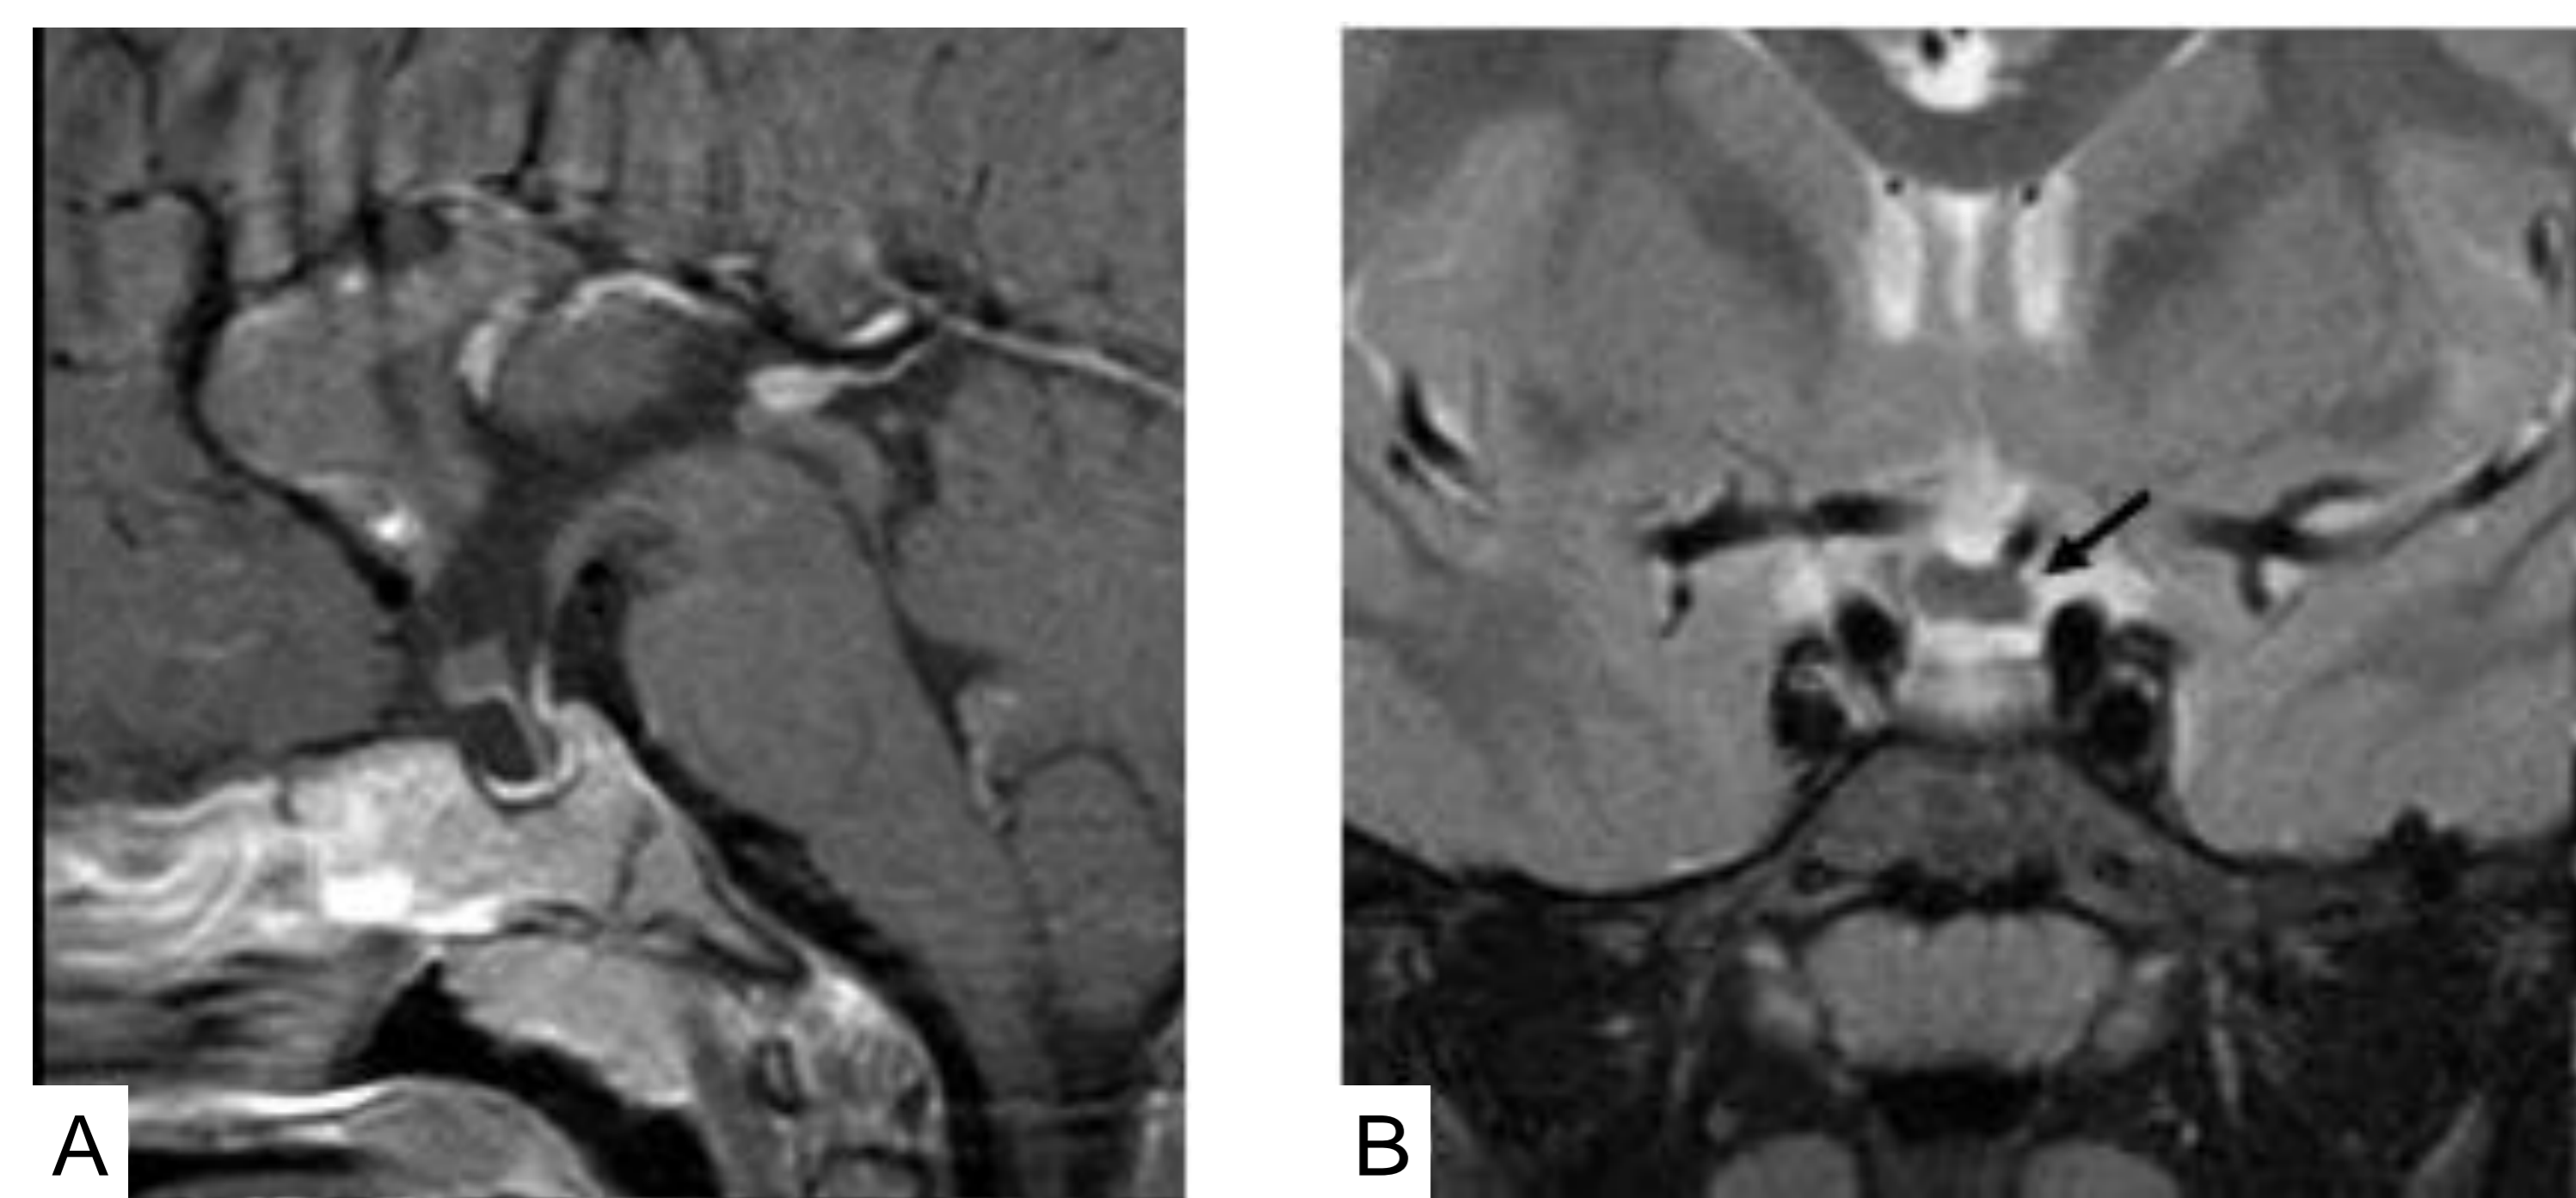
MRI sagittal T1weighted image of patient
